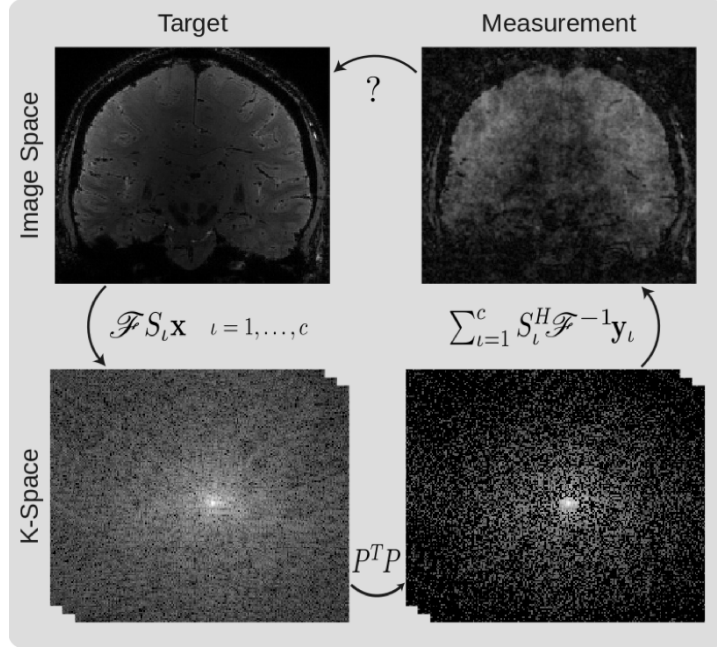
Image from [4]. Top left: Fully sampled MRI. Bottom left: k-space measurements which is related to image space through a coil sensitivity weighted map, followed by a Fourier transform. Bottom right: Accelerated measurements with subsample mask  $P$ . Top right: Reconstructed sparsely sampled k-space, where incoherent aliasing artifacts are visible. Reconstruction methods to find the function to go from the aliased MRI to the fully sampled high resolution MRI is the goal.
